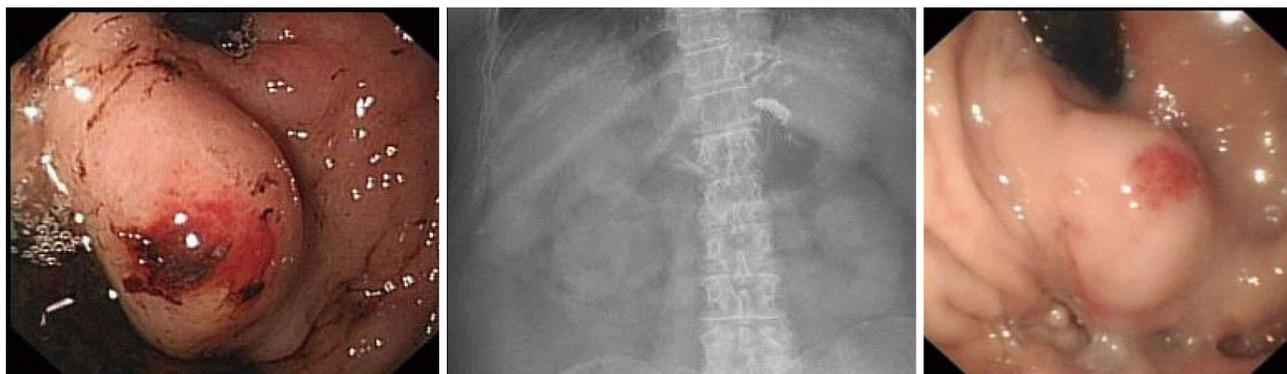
Endoscopic images of a gastric varix before and after glue therapy. The varix has become smaller and is now firm when probed. The plain radiograph between demonstrates a radio-opaque deposit in the fundus of the stomach, due to lipiodol.
